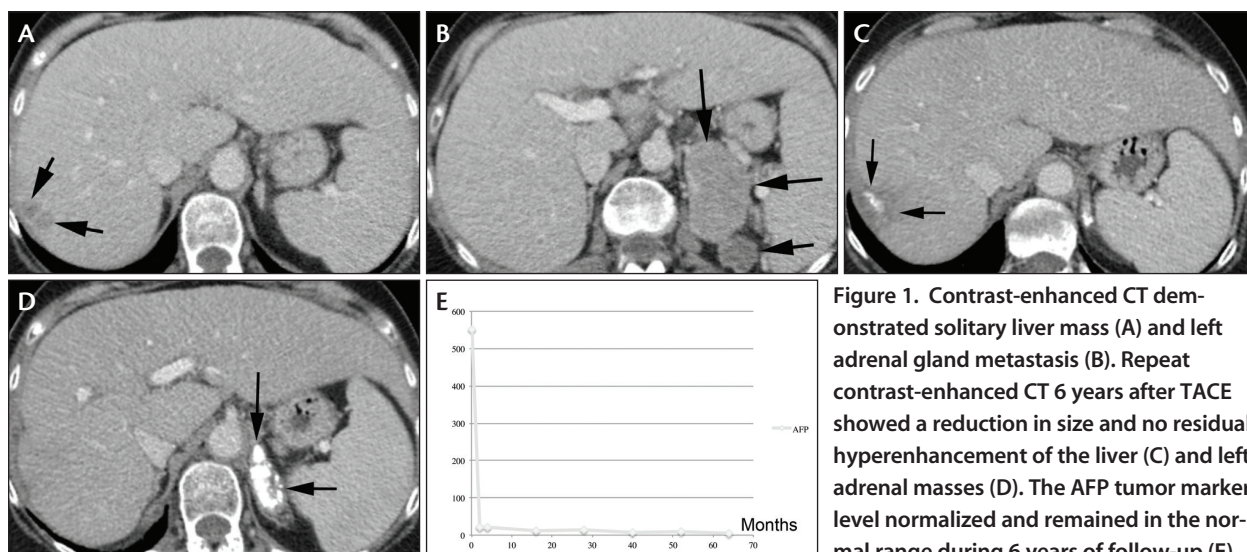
Contrast-enhanced CT demonstrated solitary liver mass (A) and left adrenal gland metastasis (B). Repeat contrast-enhanced CT 6 years after TACE showed a reduction in size and no residual hyperenhancement of the liver (C) and left adrenal masses (D). The AFP tumor marker level normalized and remained in the normal range during 6 years of follow-up (E).
